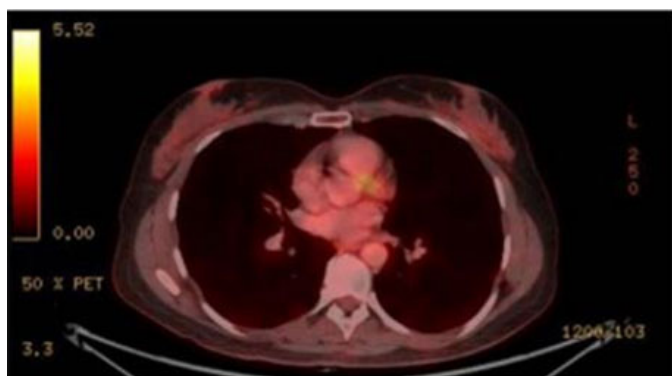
PET-CT May 2021: chest images evidence diffuse densification areas in the deep plans of the left breast, attached to the pectoral musculature, without hypermetabolism (previous SUV of 4,4).
